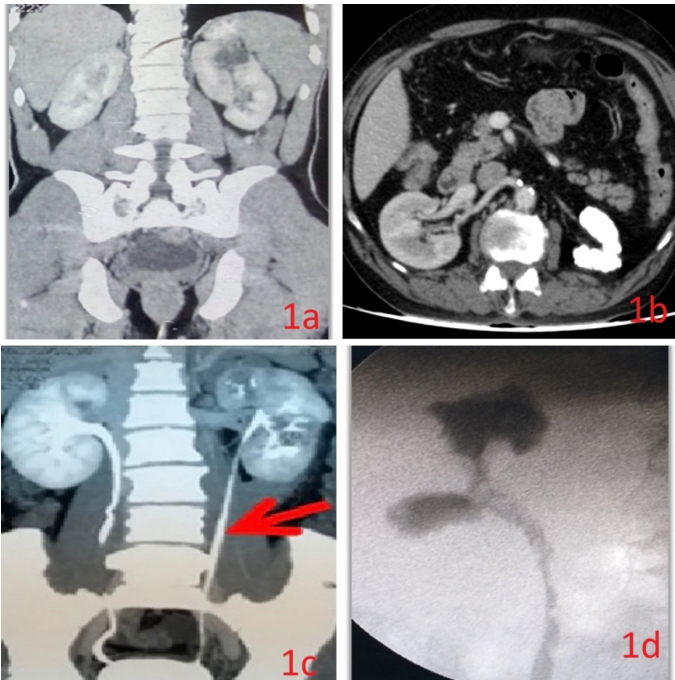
Imaging (CT/IVP/RGP) suggesting GUTB
